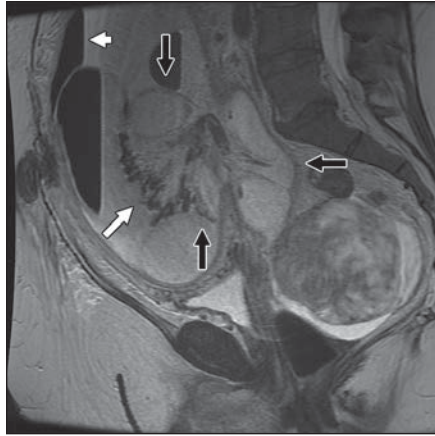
47-year-old patient with abdominal pain and closed-loop small-bowel obstruction who was diagnosed with small-bowel ischemia. Sagittal MR image shows dilated fluid-filled small bowel radiating to central point (*black arrows*). Pneumatosis intestinalis (*long white arrow*), mesenteric venous gas, and pneumoperitoneum (*short white arrow*) are also shown.
